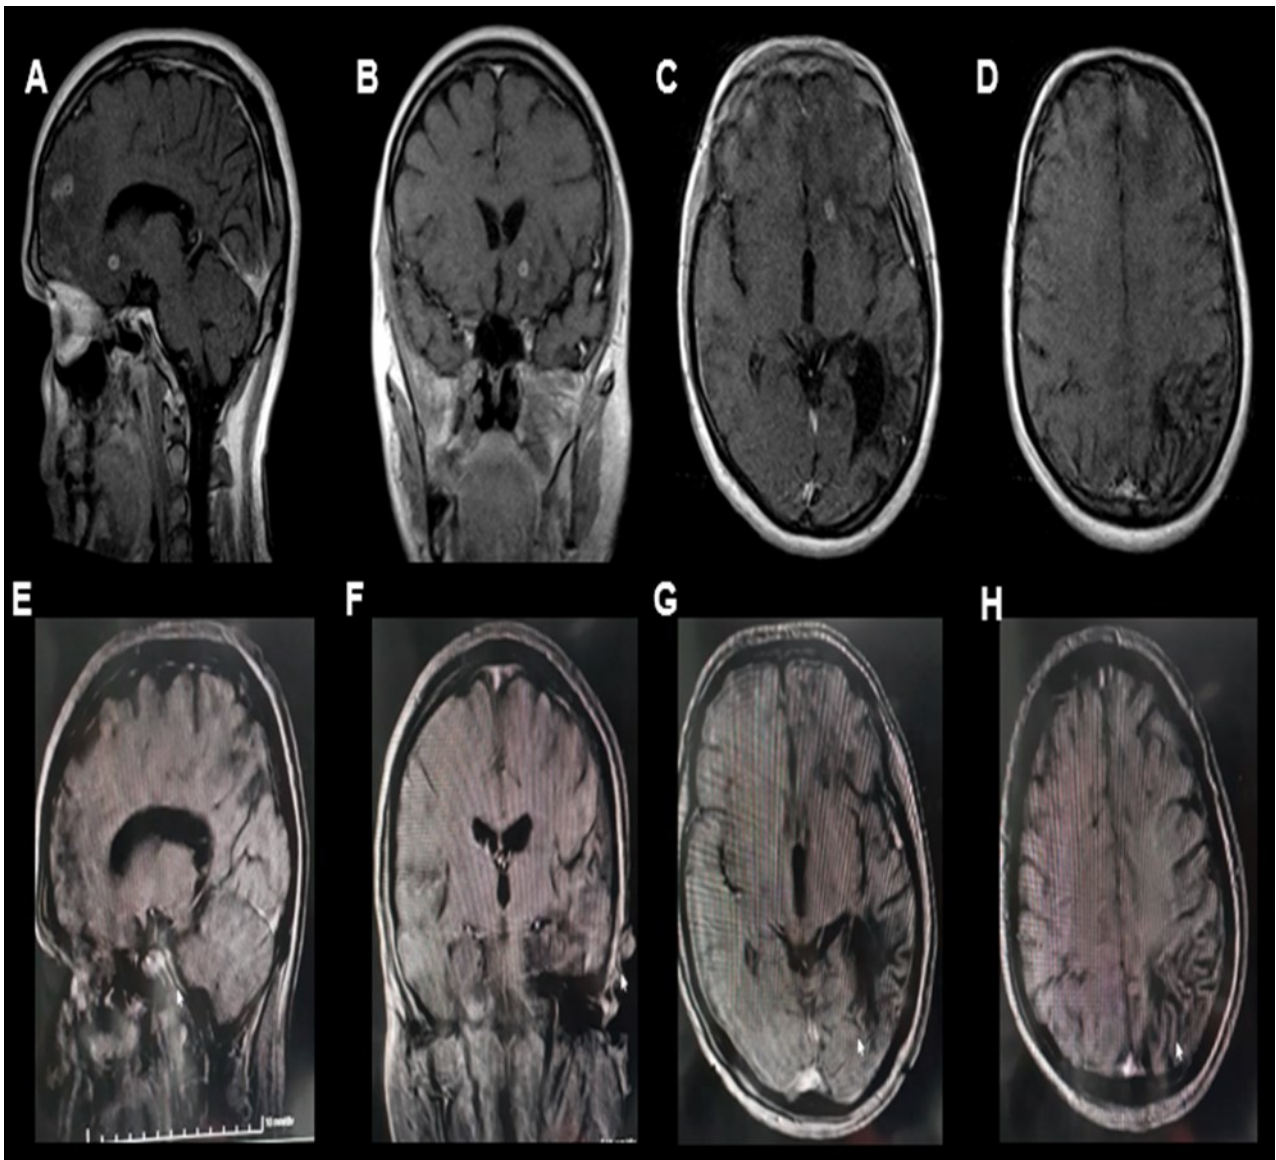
Magnetic resonance images, coronal and axial sagittal sections, respectively, preoperative (A, B, C, D), where two annular lesions with perilesional edema and contrast uptake are observed in the frontal and left parathalamic regions, 18x15x18mm and 14x15x15mm respectively; and postoperative 3 months later (E, F, G, H) where the absence of lesions is visualized.
